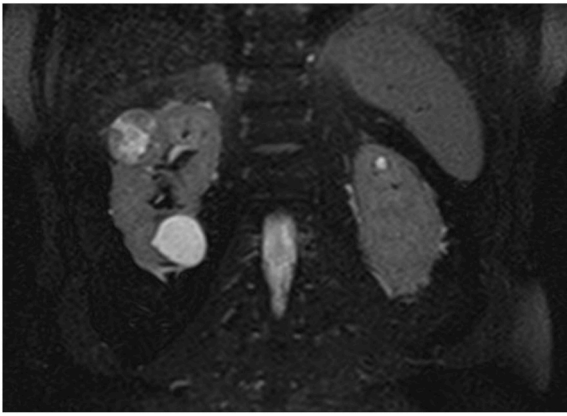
Coronal MRI T2 demonstrating 3.9cm upper pole renal mass in the right kidney.
